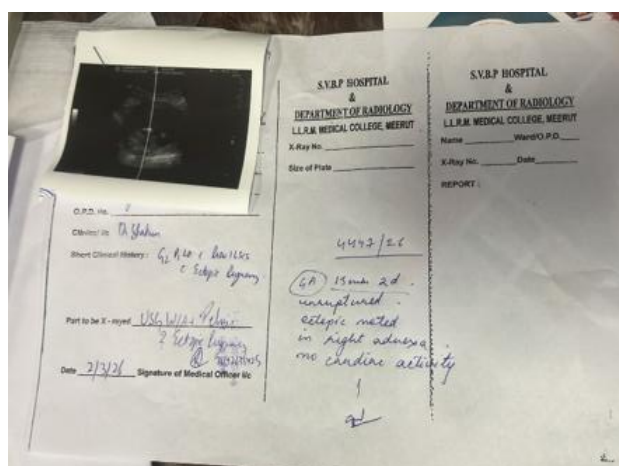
Preoperative ultrasonography demonstrating a right-sided ectopic gestation corresponding to approximately 12 weeks with absent fetal cardiac activity.
